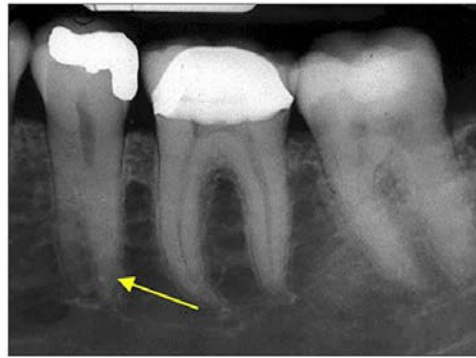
Periapical radiograph of supernumerary tooth root #20.
